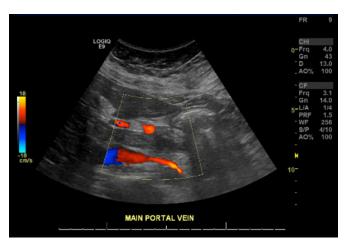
Color-flow doppler of main portal vein showing no flow.
